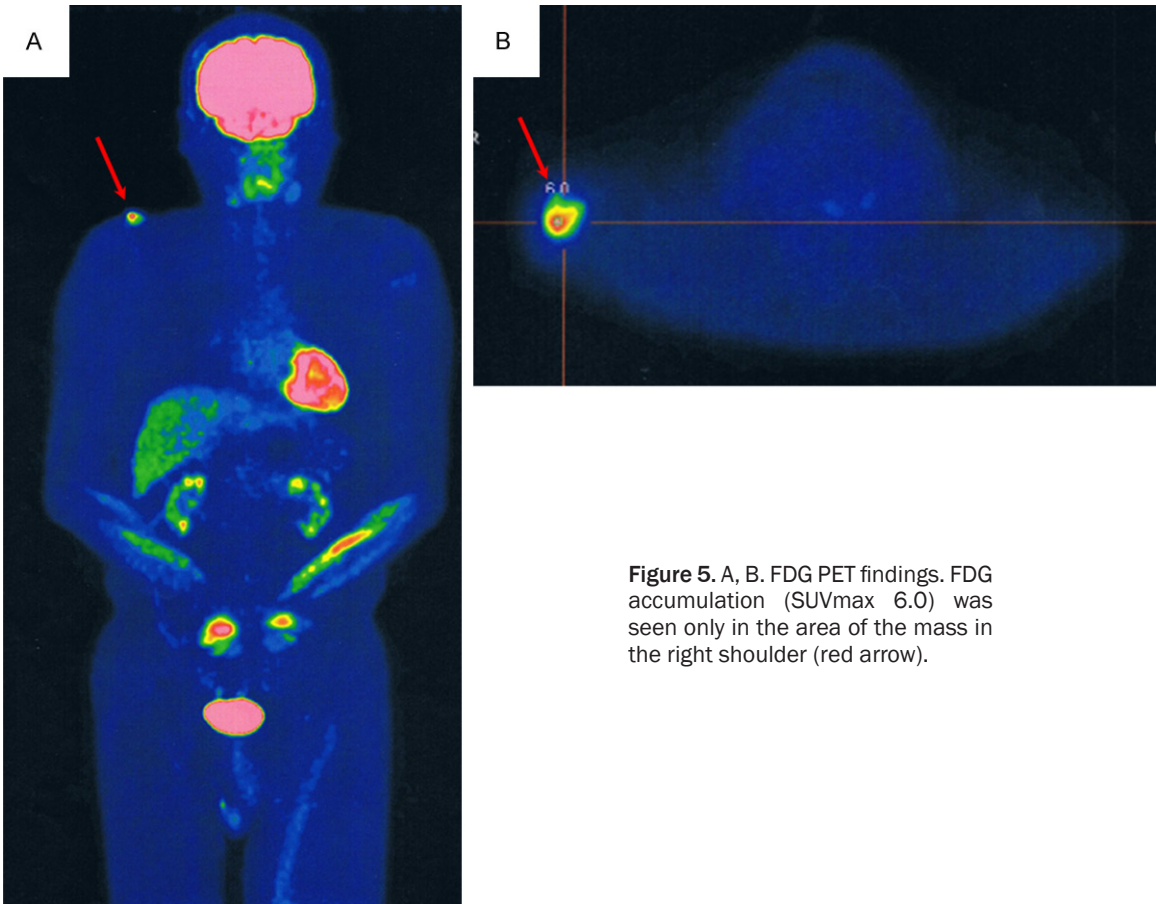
A, B. FDG PET findings. FDG accumulation (SUVmax 6.0) was seen only in the area of the mass in the right shoulder (red arrow).
